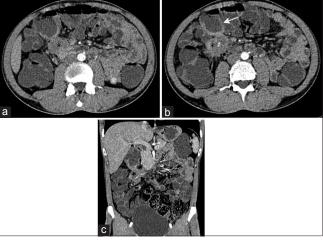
Contrast-enhanced computed tomography enterography (a and b) axial and coronal (c) sections showing a hypoenhancing mesenteric mass having spiculated margins (asterisk) causing contiguous involvement and thickening of the duodenum as well as the proximal transverse colon (white arrow). The mass is encasing the ileocolic artery (black arrow)
